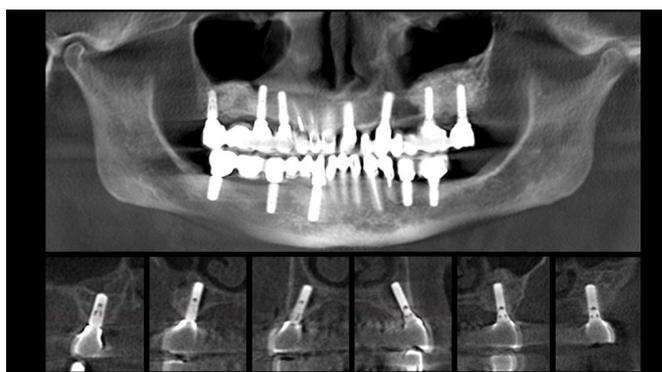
CBCT scans 12 years after the delivery of the final prosthesis.
